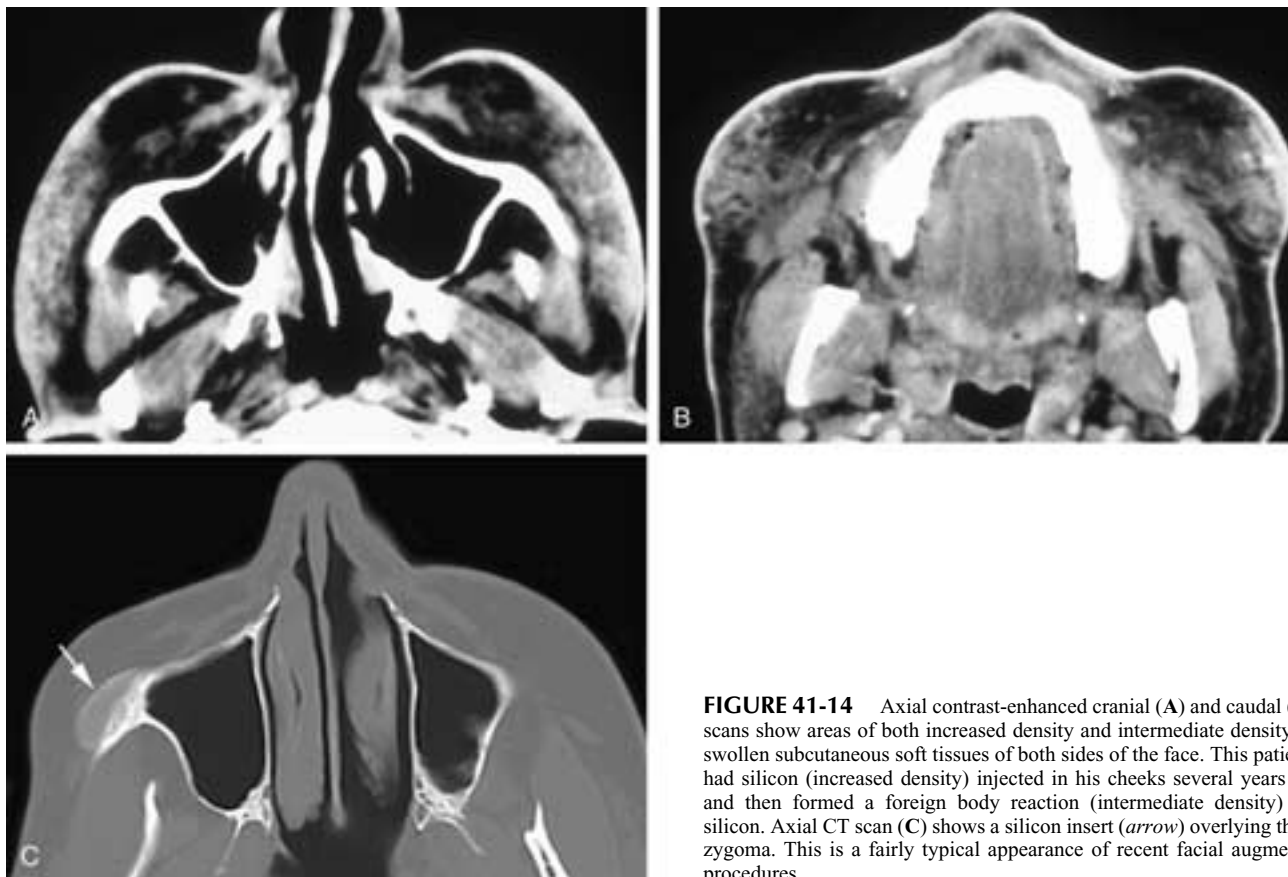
Axial contrast-enhanced cranial (A) and caudal (B) CT scans show areas of both increased density and intermediate density in the swollen subcutaneous soft tissues of both sides of the face. This patient had had silicon (increased density) injected in his cheeks several years earlier and then formed a foreign body reaction (intermediate density) to the silicon. Axial CT scan (C) shows a silicon insert (*arrow*) overlying the right zygoma. This is a fairly typical appearance of recent facial augmentation procedures.
